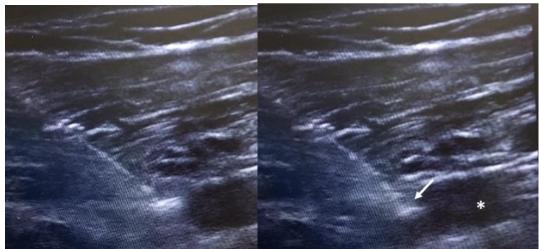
Inserting the puncture needle under sonographic guidance using a long axis/inplane technique. Puncture needle tip (arrow), access vein (asterisk).
